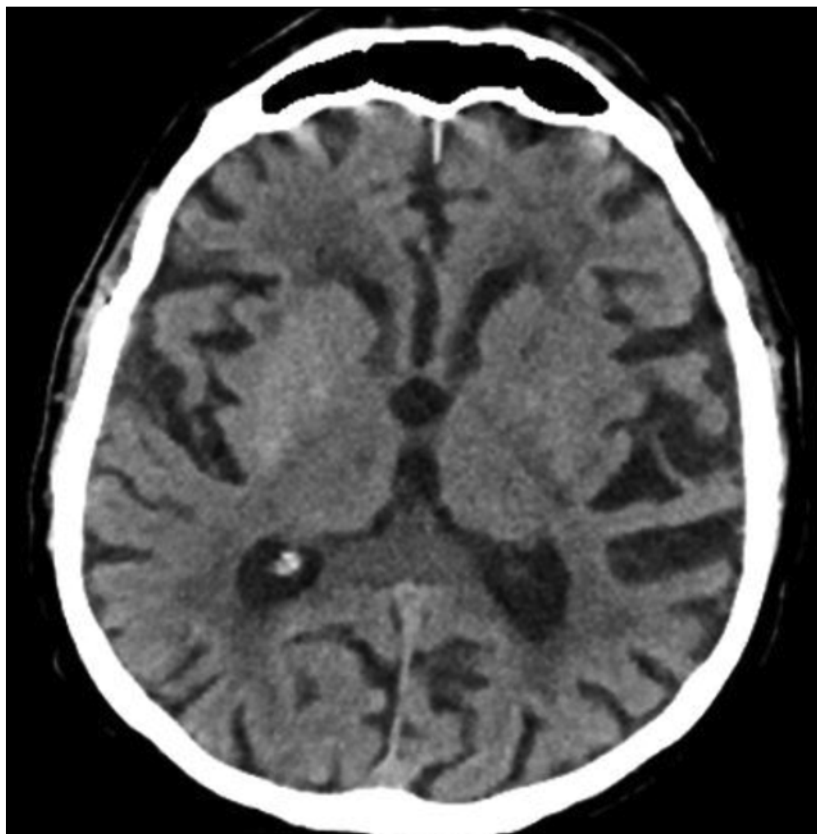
CT scan at admission
